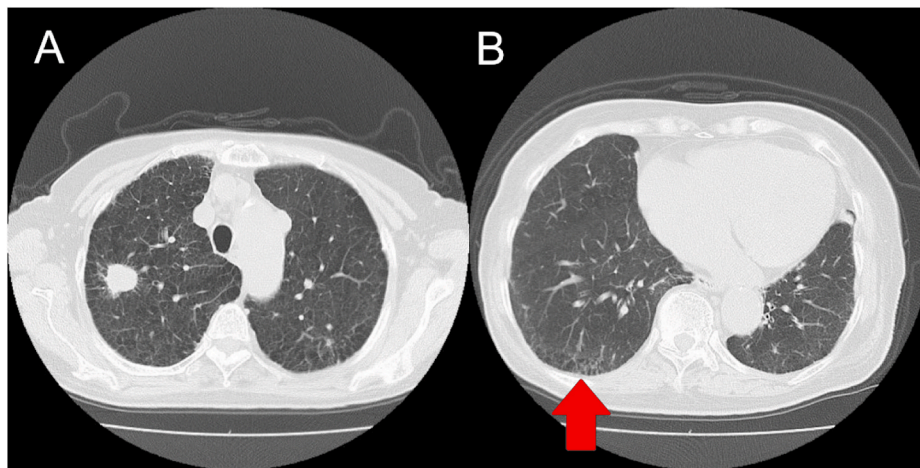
Chest computed tomography at the first time of diagnosis. The image shows a 21 × 23 mm mass in the right upper lobe (A) and usual interstitial pneumonia pattern in the lung base (B, arrow).
